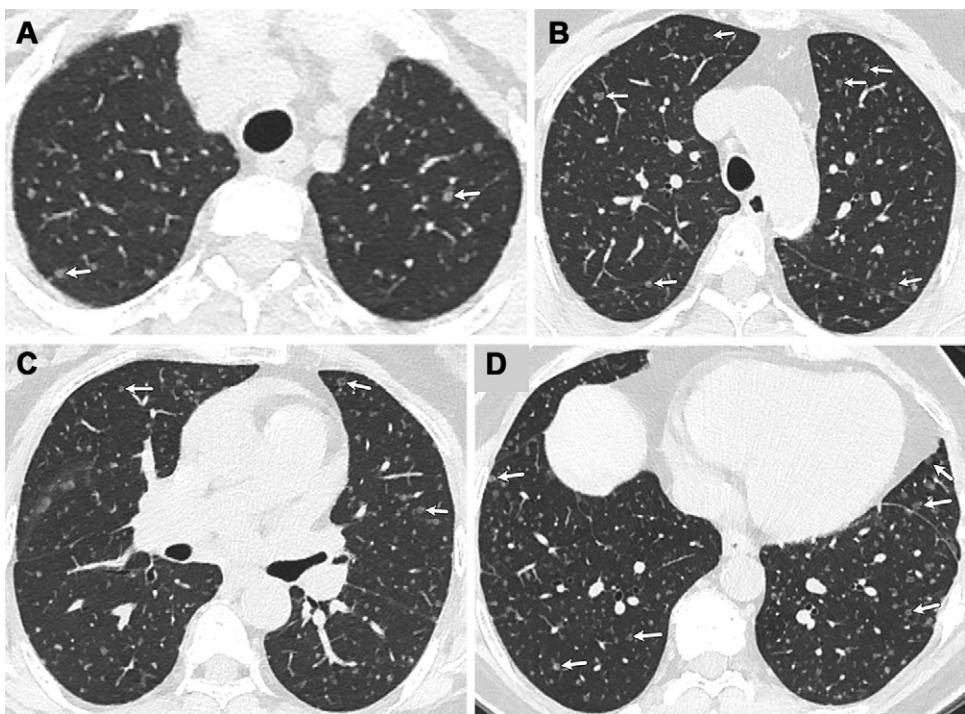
Axial unenhanced thin-section chest CT images obtained at current presentation. Selected images from (A) apices, (B) arcus aorta, (C) lingular bronchus, and (D) lower lung using lung window settings ($64 \times 0.625\text{-mm}$ collimation, 100-kV tube voltage, 350-mA tube current, 512×512 matrix, and 1.0-mm section thickness). Images were also reconstructed with 0.5-mm section thickness using a high-spatial-frequency algorithm. There are multiple, randomly distributed small (≤ 6 mm) ground-glass nodules. Again, some of the nodules include central lucencies (ringlike appearance) (arrows).
